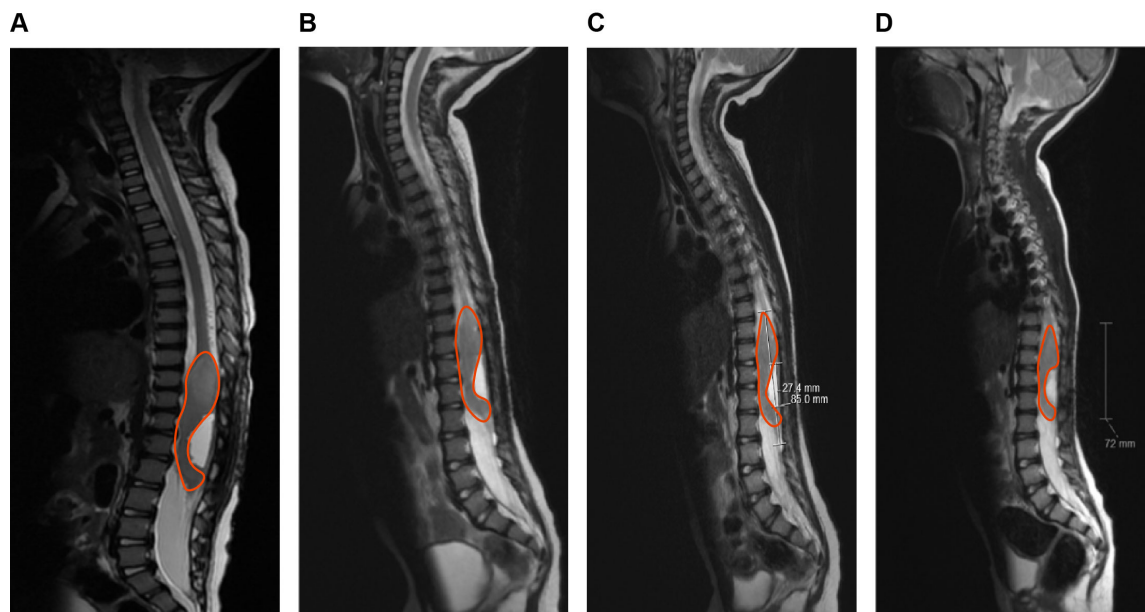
MRI scans during treatment. A, MRI T2 weighted sagittal image of the spine post-surgery. B, MRI T2 weighted sagittal image of spinal tumour at baseline after chemotherapy. B, MRI T2 weighted sagittal image post cycle 2 of larotrectinib. C, MRI T2 weighted sagittal image post cycle 12 of larotrectinib. Tumour is outlined by a red line in each image.
